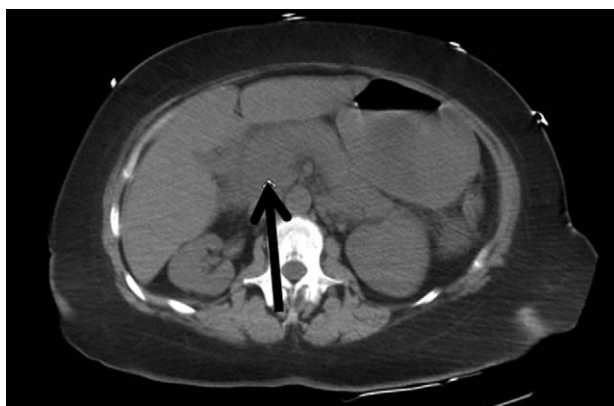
Computed tomography scan of the abdomen demonstrating pancreatic head enlargement (arrow).
